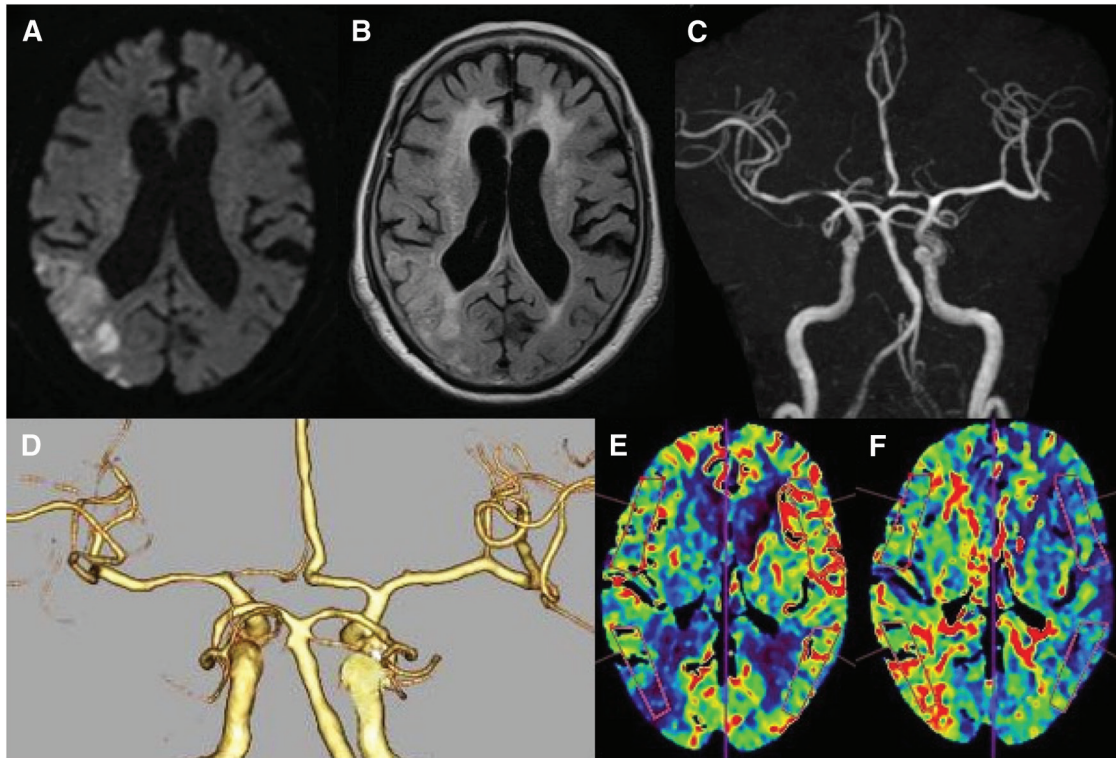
MRI images on day 2 and enhanced CT images on day 6. (A) DWI showing no new HIA. (B) FLAIR showing HIA along the posterior region of the MCA, which exhibited an HIA on DWI at admission. (C and D) MRA and CTA showing the reperfusion and remaining right M1 stenosis. (E and F) CT perfusion indicates hypoperfusion of the MCA region; rCBF value decreased and the MTT was significantly longer on the right. DWI: diffusion-weighted imaging; HIA: high-intensity area; MCA: middle cerebral artery; MTT: mean transit time; rCBF: regional cerebral blood flow
